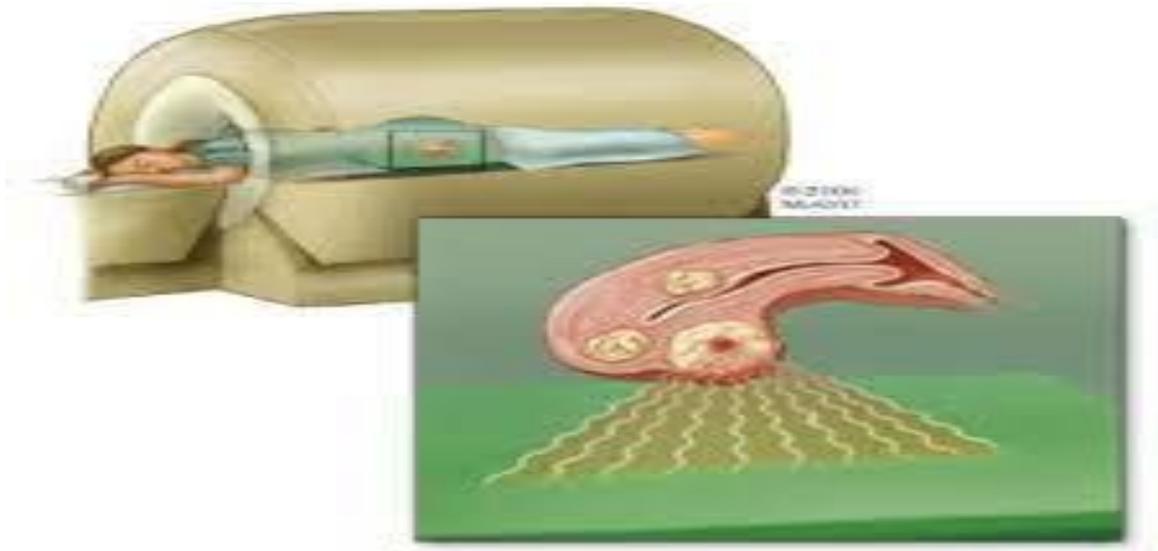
Magnetic resonance-guided focused ultrasound surgery (MRgFUS) ( Abe et al ., 2020)
